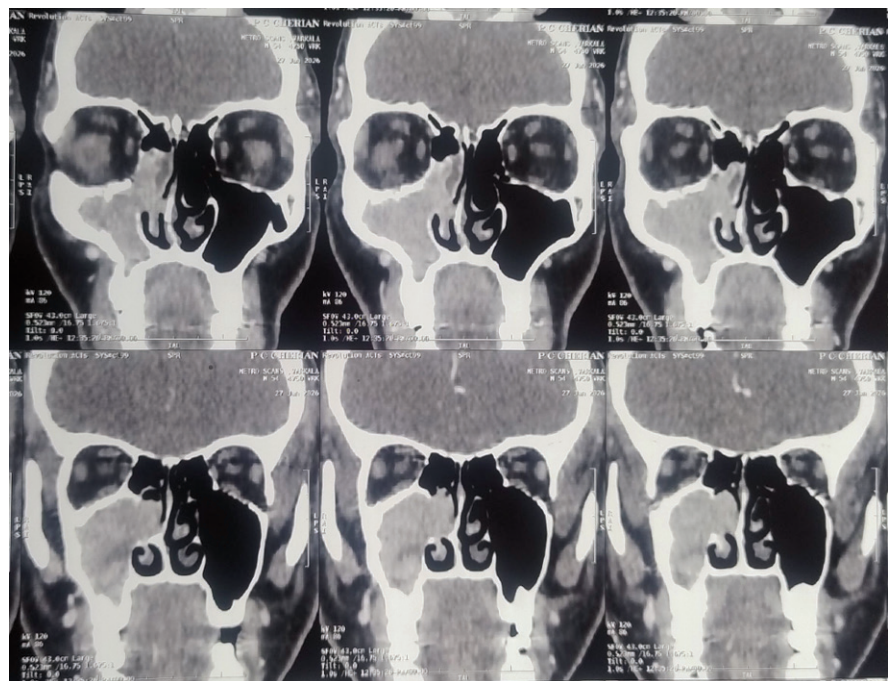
Contrast-enhanced computed tomography of paranasal sinuses
